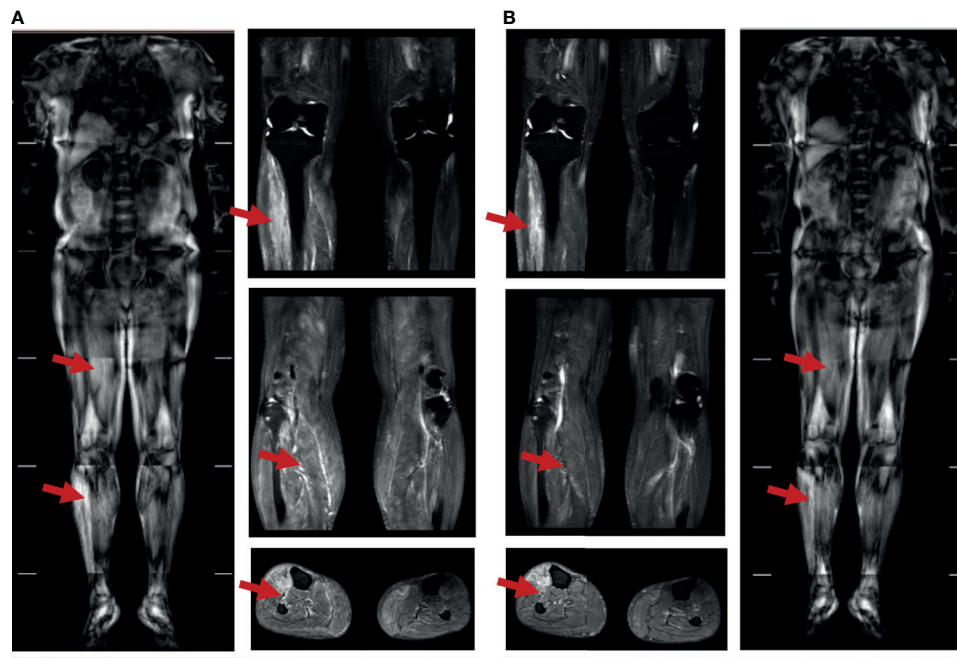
(A) Muscle MRI of 5 weeks after immunotherapy: diffuse strip-shaped high-signal shadows were seen in the back and lower limbs, as indicated by the red arrows; (B) Muscle MRI of 10 weeks after immunotherapy: high-signal shadows receded after 40 days of glucocorticoid treatment, especially in the right lower limbs, as indicated by the red arrows.
